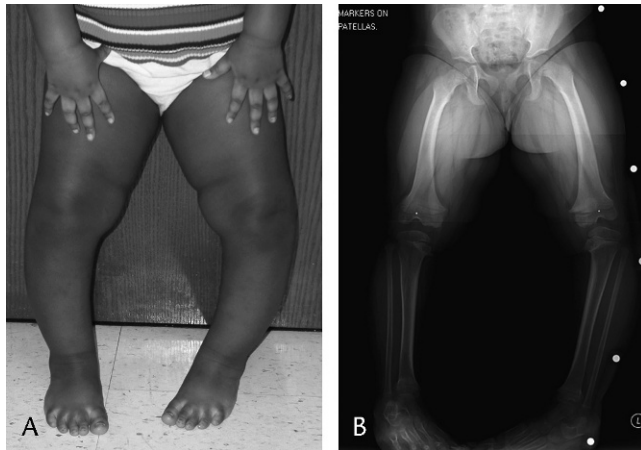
A, Clinical appearance of a 3-year-old girl with bilateral early-onset Blount disease, with the left side more severe than the right side with associated internal tibial torsion deformities. B, Standing AP radiograph of same patient with use of metal markers overlying the patellae to verify the knee forward position of the lower extremities. Radiographic magnification markers can be seen on the patients left side.
